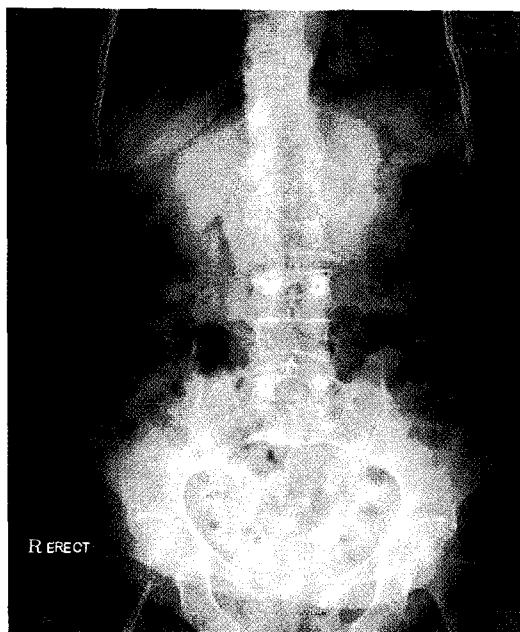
There was seen calcification on LUQ in abdomen x-ray image.
